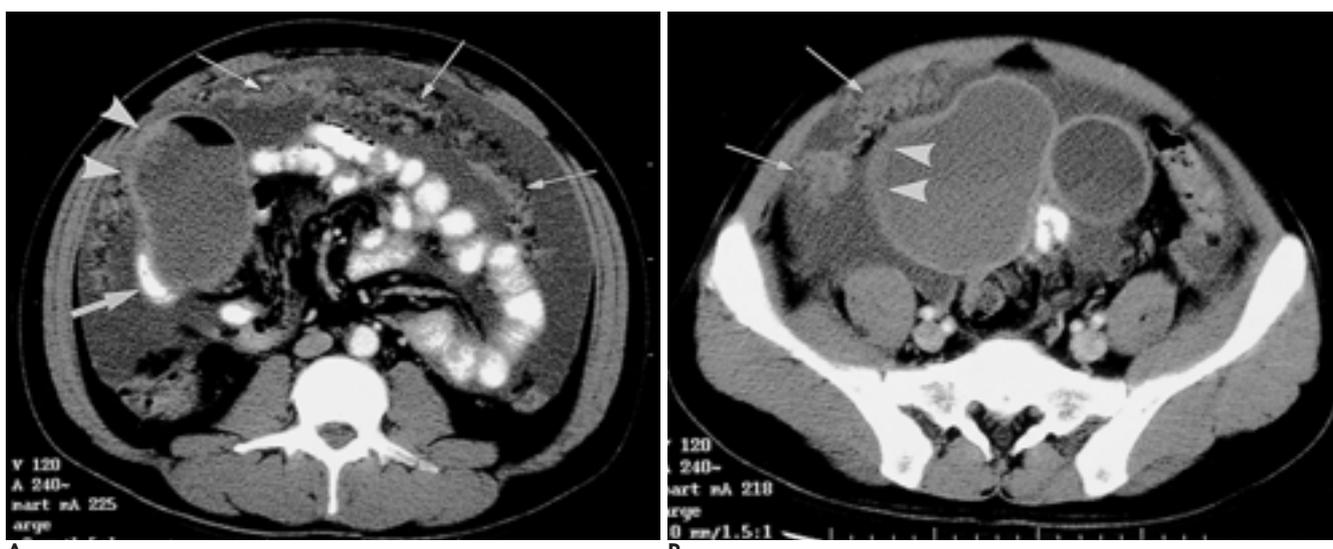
Abdominal CT after contrast enhancement.
